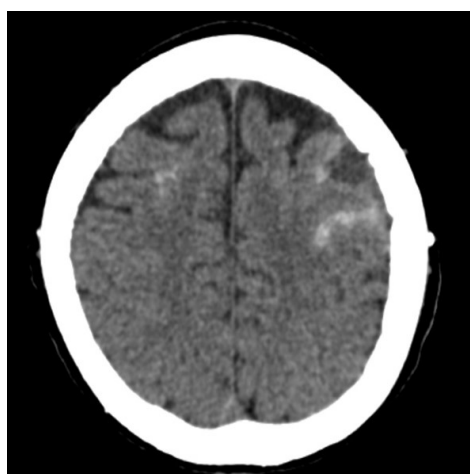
Plain Computed tomography (CT) scan of the brain showed multiple acute subarachnoid haemorrhages.
